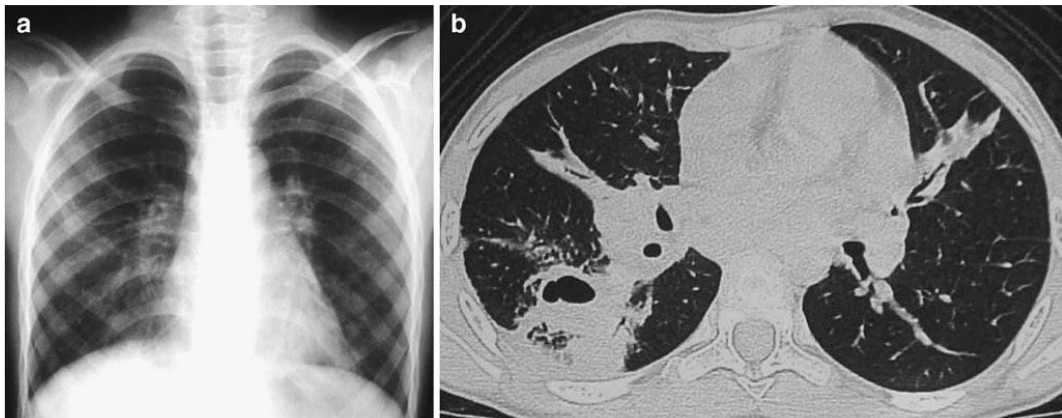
A 6-year-old girl (CP) with constitutional symptoms and a positive tuberculin skin test. a Chest radiograph shows a thin-walled cavity in the right mid-zone. b CT (lung windows) demonstrates
